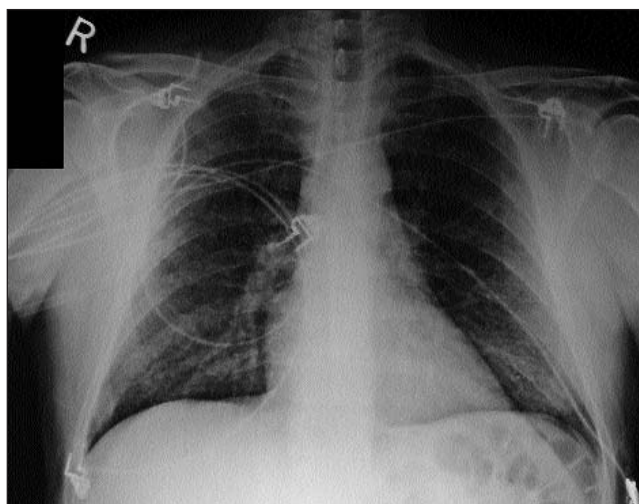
Admission plain chest radiograph. Note the bilateral micronodular radiodensities, more marked in the lower lung zones
